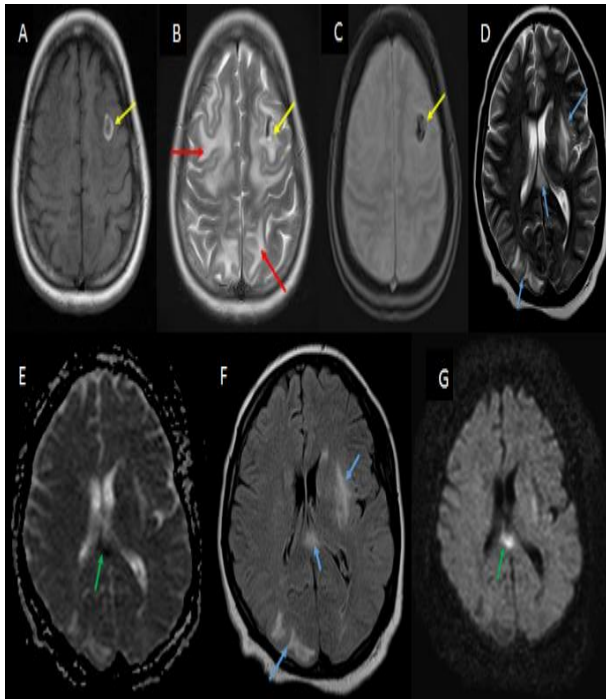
(A-G): (I) A 35-year-old female presented with headache and seizure on the third day of post-spontaneous vaginal delivery. MR imaging showed atypical features of PRES: Axial T1W (A), axial T2W (B) and axial T2* (C). (II) A 25-year-old female presented with headache, seizure, and visual disturbances on the second day of post spontaneous vaginal delivery. MR imaging showed atypical features of PRES: axial T2W (D), axial DWI (E), axial FLAIR (F) and axial ADC (G).
